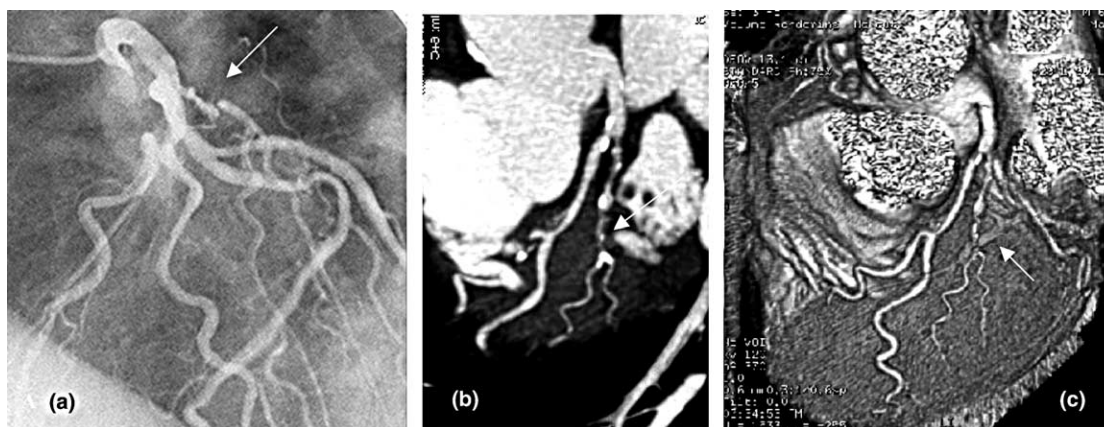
(a) Angiogram (LAO, CC) shows the presence of multiple stenoses on the ramus intermedius. (b) MSCT (MIP) shows multiple stenoses on the ramus intermedius. (c) MSCT (volume rendering) shows multiple stenoses on the ramus intermedius. CC: cranio-caudal; LAO: left anterior oblique; MIP: maximum intensity projection; MSCT: multislice computed tomography.
